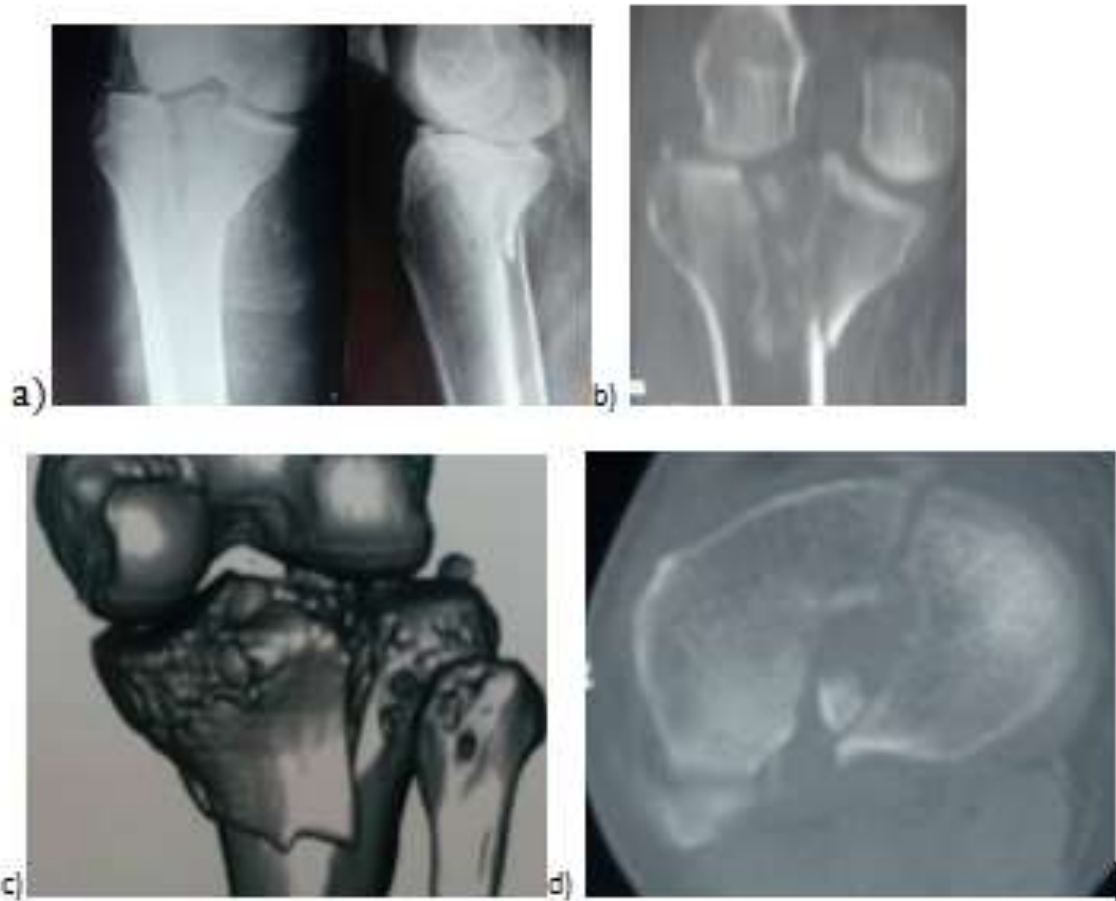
a to 42.d Showing Preop X-rays and CT.
